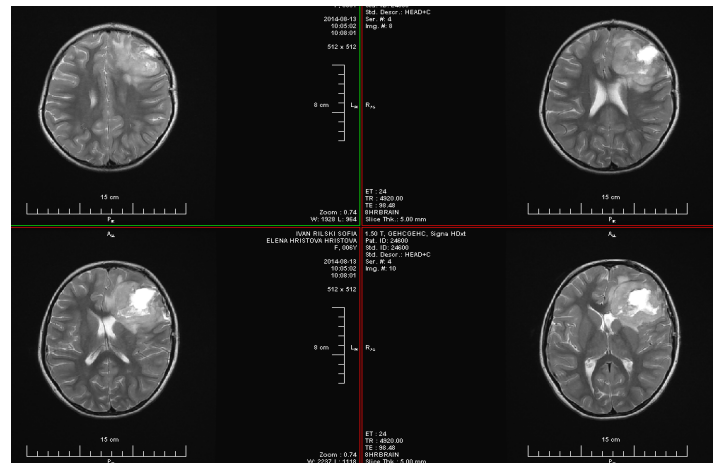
Axial MRT-FLAIR images of a frontoparietal tumor, located on the left with non-homogeneous postcontrast accumulations with approximate edema and mass-effect.
